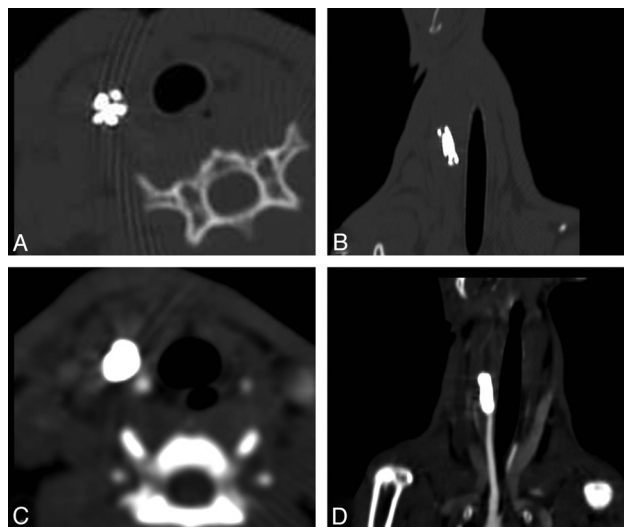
CT images of a coiled carotid bifurcation aneurysm. Note the reduced artifact production and visibility of individual coils on the unenhanced CT scan (A and B). CTA shows complete occlusion of the aneurysm and minimal artifact production (C and D).
